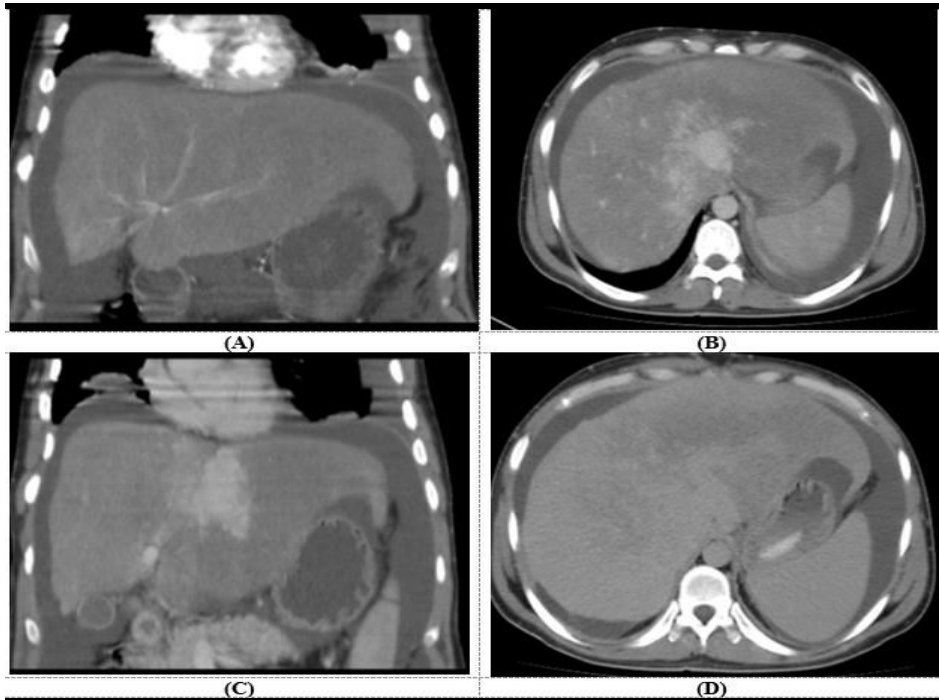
40-year-female patient presented to our department complaining of abdominal pain. (A) Coronal CT image (arterial phase) shows enlarged size liver attenuated hepatic veins. Gallbladder shows increased wall thickness without gallstone. Moderate ascites with associated left sided pleural effusion. (B) & (C) Axial and coronal CT images (Porto-venous phase) showing enhancement of the caudate lobe and central liver around the inferior vena cava, inhomogeneous mottled liver (nutmeg liver). Peripheral zones of the liver appear hypoattenuating because of reversed portal venous blood flow. (D) Axial CT (Delayed phase) image showing delayed enhancement of the peripheral liver with accompanying central low density (flip-flop appearance). CT picture suggesting; Budd-Chiari syndrome.
